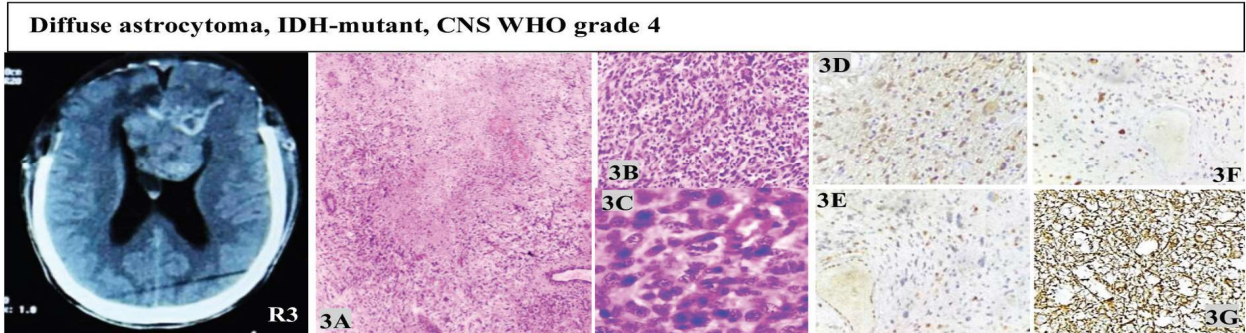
Fig. R3 MRI showed a heterogeneously enhancing fronto-parietal mass with central necrosis, vasogenic edema, and midline shift. Histomorphology (Fig. 3A-3C) showed diffusely infiltrating atypical cells with geographic necrosis, increased cellularity, microvascular proliferation, marked atypia, & mitoses. IHC showed IDH mutation (Fig. 3D), ATRX loss (Fig. 3E), p53 positivity in 30-40% of tumor cells (Fig. 3F) and diffuse GFAP positivity (Fig. 3G).
